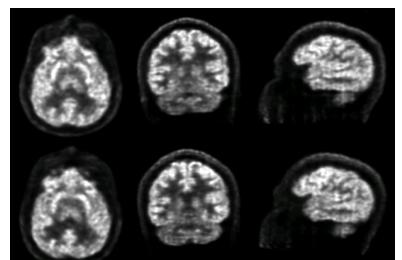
FDG-PET uptake image of minute 40 to 60 post injection; (Top) No MR acoustic stimuli between minutes 0 to 40; (Bot.) MR acoustic stimuli present for minutes 0 to 60.
